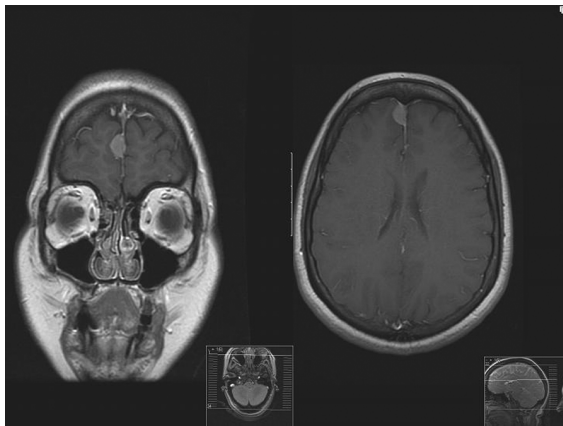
Gadolinium enhanced MRI Brain 1.5 cm right parafalcine tumour cavernously posteriorly to abut the anterior surface of the pons/mid-brain.
